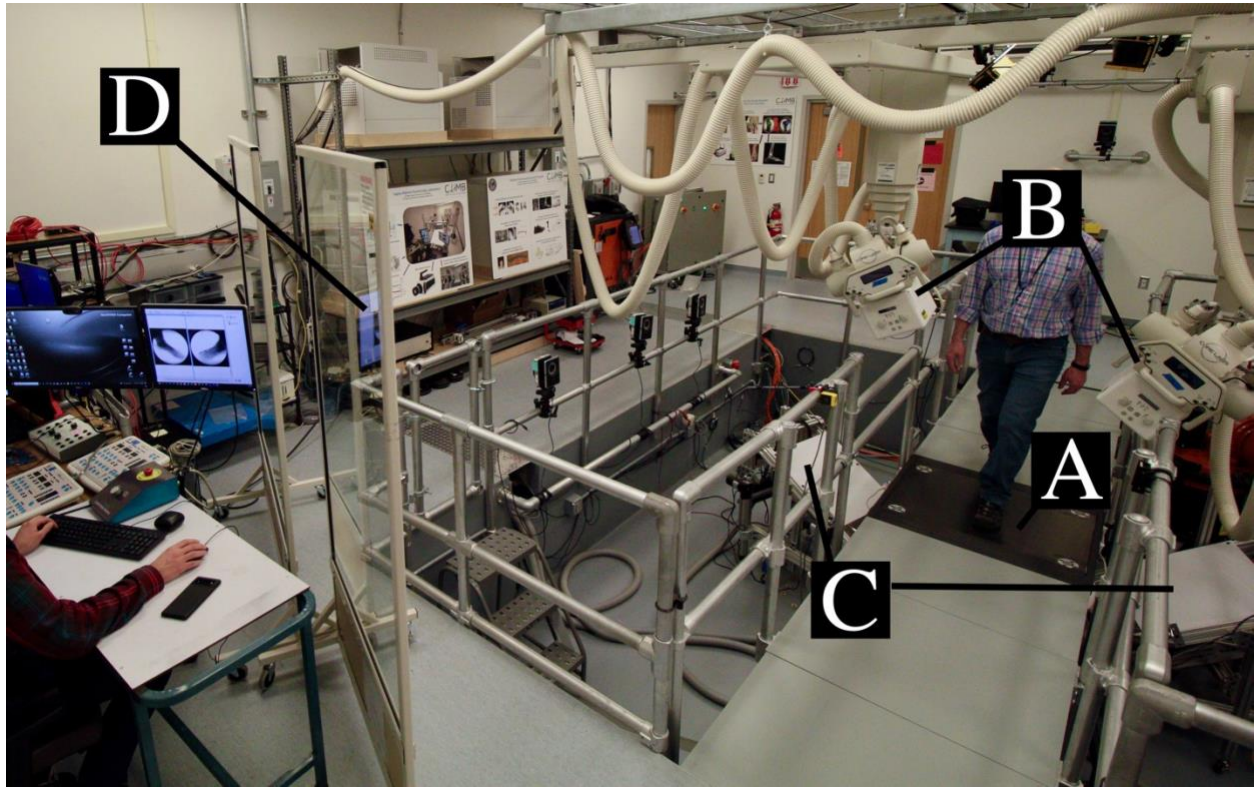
Biplanar fluoroscopy system configured to obliquely image the foot and ankle through a custom walkway with a minimally X-ray attenuating carbon fiber force plate panel (A). The system consists of synchronously pulsed X-ray sources (B) aimed at image intensifiers coupled with high-speed cameras (C). Operators control the system safely from behind X-ray shielding (D).
